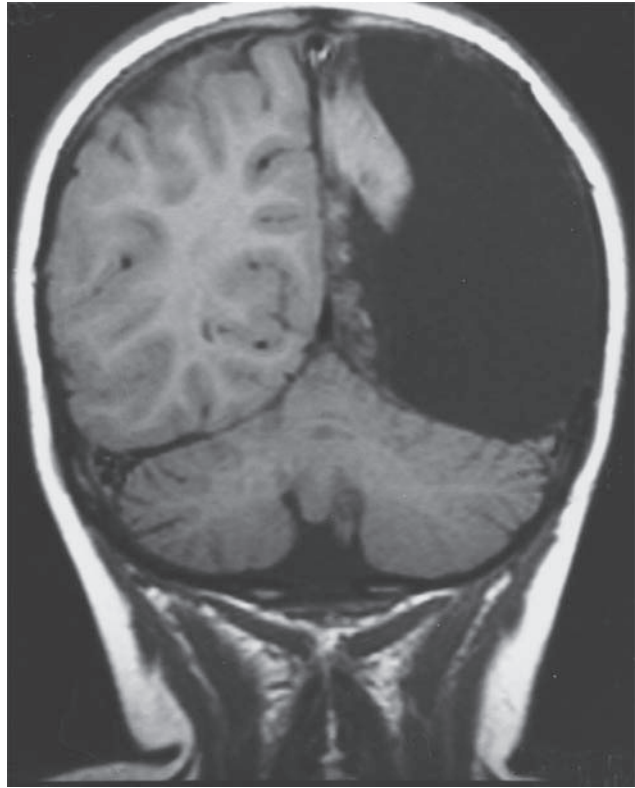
Do you really need a cortex? A structural brain scan (MRI) from a 7-year-old girl who had a surgical removal of her left hemisphere at age 3 for Rasmussen’s encephalitis. Such surgeries can save children’s lives if they are performed early enough. Because the brain is highly flexible at this age, the language capacity has shifted to the right hemisphere. Notice, however, that her brainstem and thalami are intact. The brainstem is crucial to life functions, and cannot be removed. She is able to play and talk, and has mild right side motor impairment. *Source:* Borgstein and Grotendorst, 2002.
